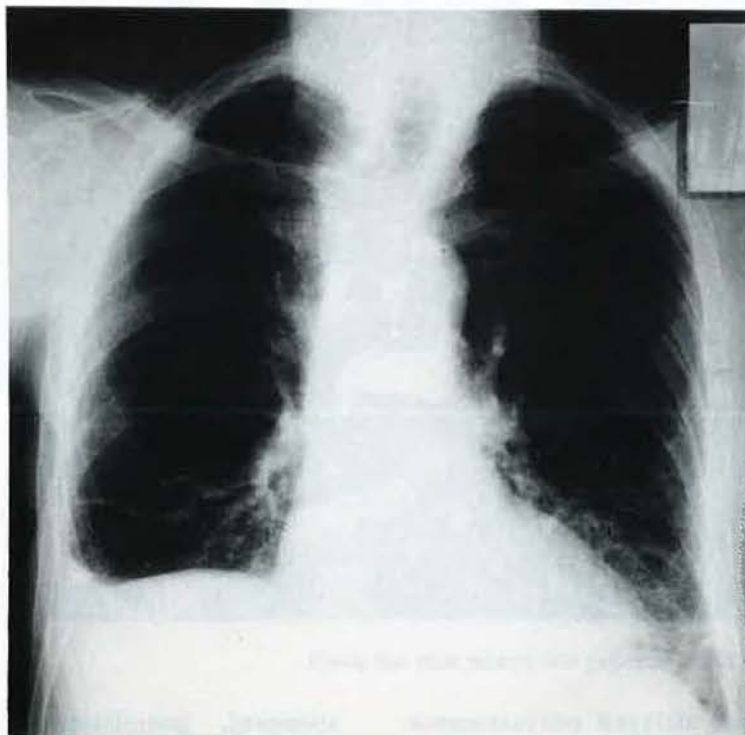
Chest radiograph after two months of therapy.
